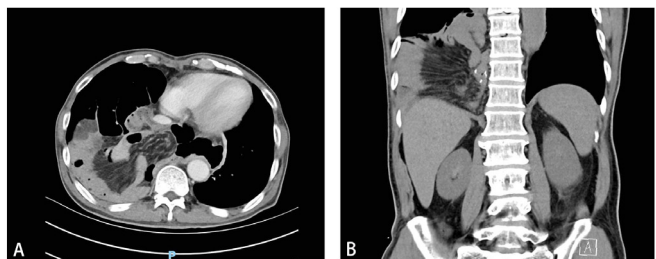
Thoracoabdominal CT scan showing partial herniation of the small intestine into the right thoracic cavity, compressing the right lung.
